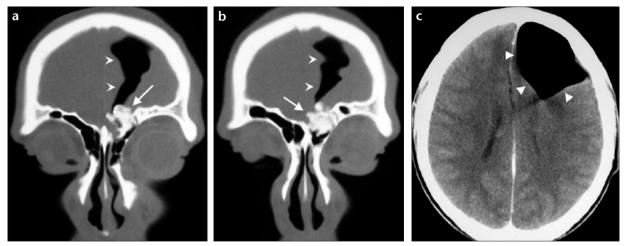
a-c. Coronal paranasal CT images (a, b) demonstrate an osseous lesion with well-defined lobulated contours extending into the left anterior cranial fossa (*arrows*) with accompanying intracerebral air collection (*arrowheads*). Axial cranial CT (c) shows intracerebral extention of the air collection causing parenchymal compression in the left frontal lobe (*arrowheads*).
